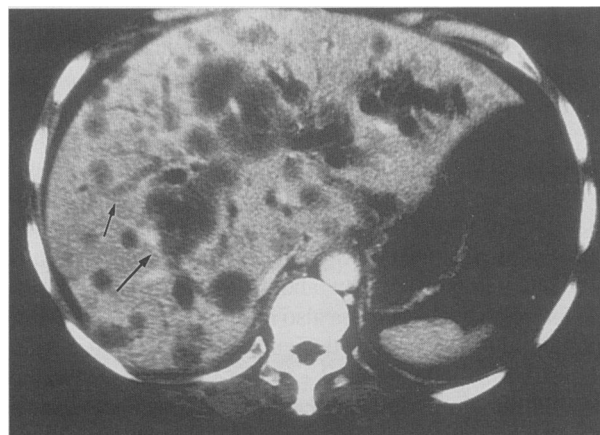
An abdominal computed tomographic study shows multiple masses throughout the liver (long arrow) and dilated intrahepatic biliary ducts (short arrow).
